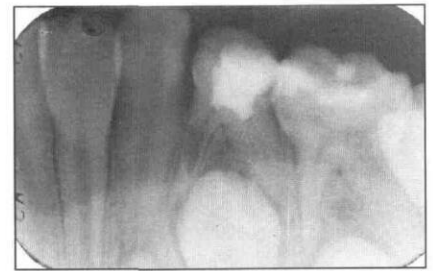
Radiographic failure of first primary molar treated with formocresol due to internal resorption. Preoperative radiograph (1a, left). Radiograph at 3-month postoperative period with internal resorption within the mesial root canal (1b).
